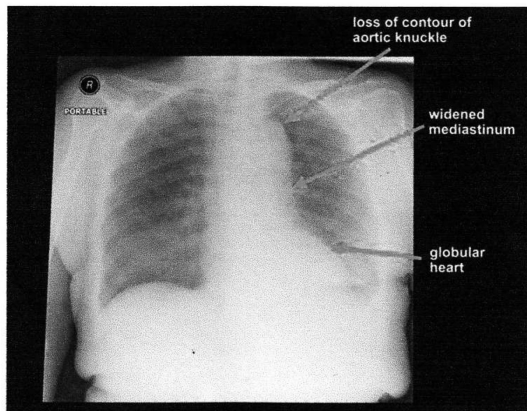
Chest x-ray showing widening of mediastinum
